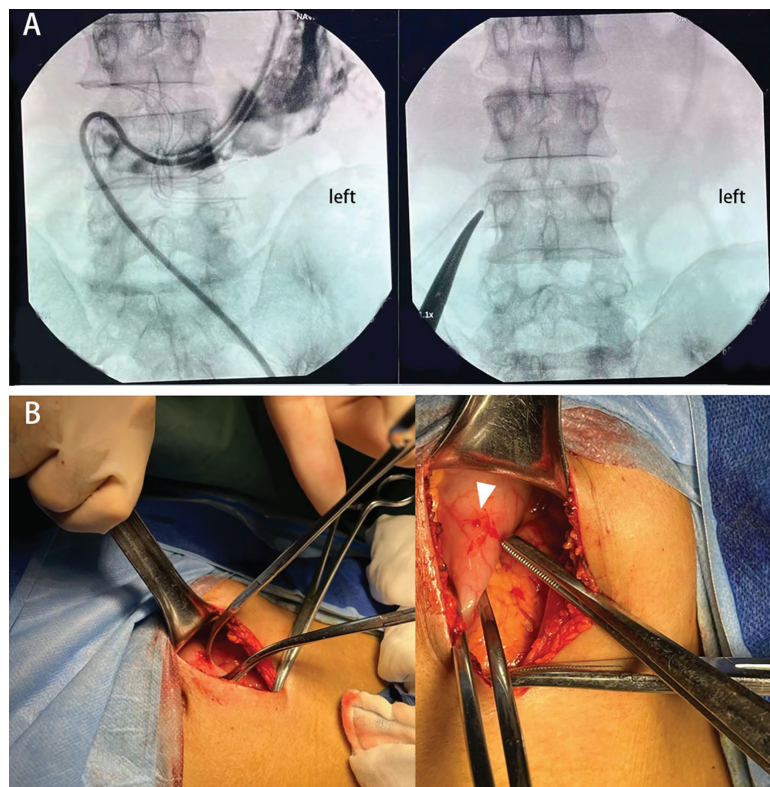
A) Intraoperative X-ray image: radiographic imaging was obtained intraoperatively. Contrast through PD catheter indicated gastric perforation. B) Open surgery confirmed the gastric perforation (white arrowhead).
